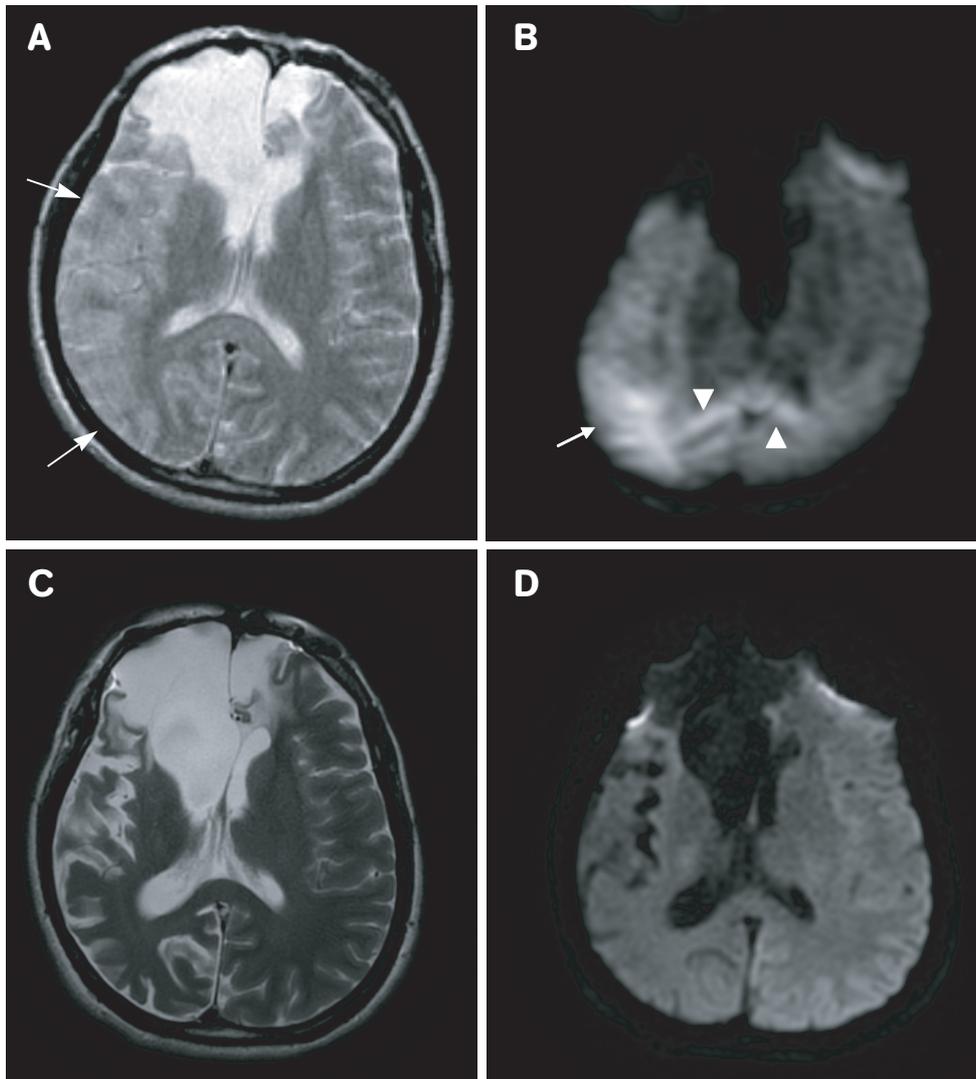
Figure (A) A T2-weighted MRI 3 days after seizure episode showed high signal intensity lesions over the right fronto-parietal lobe (arrows). (B) A diffusion-weighted MRI sequence showed a high signal intensity in splenium (arrowheads) and in the corresponding edematous areas as shown in Figure 2A (arrow). (C) A T2-weighted MRI 4 months after the onset of seizure showed resolved signals of cerebral edematous changes with atrophy in the right frontoparietal areas. (D) A diffusion-weight MRI 4 months after the onset of seizure showed resolved signals in the right fronto-parietal area and splenium.
